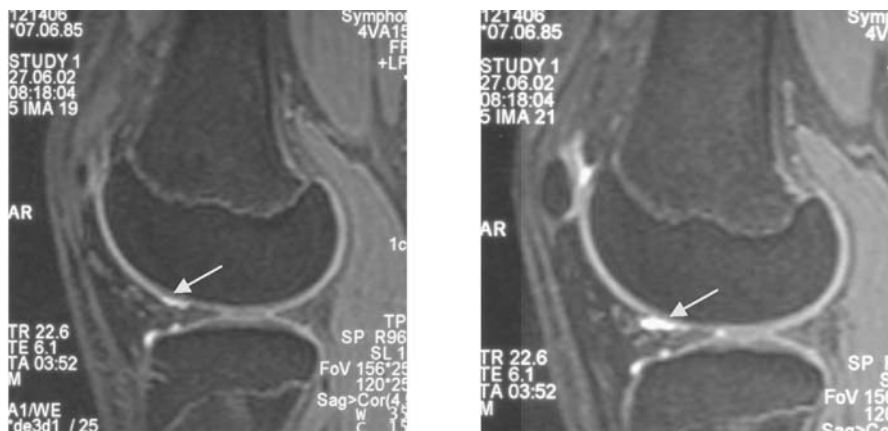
MRI, DESS 3D right knee
